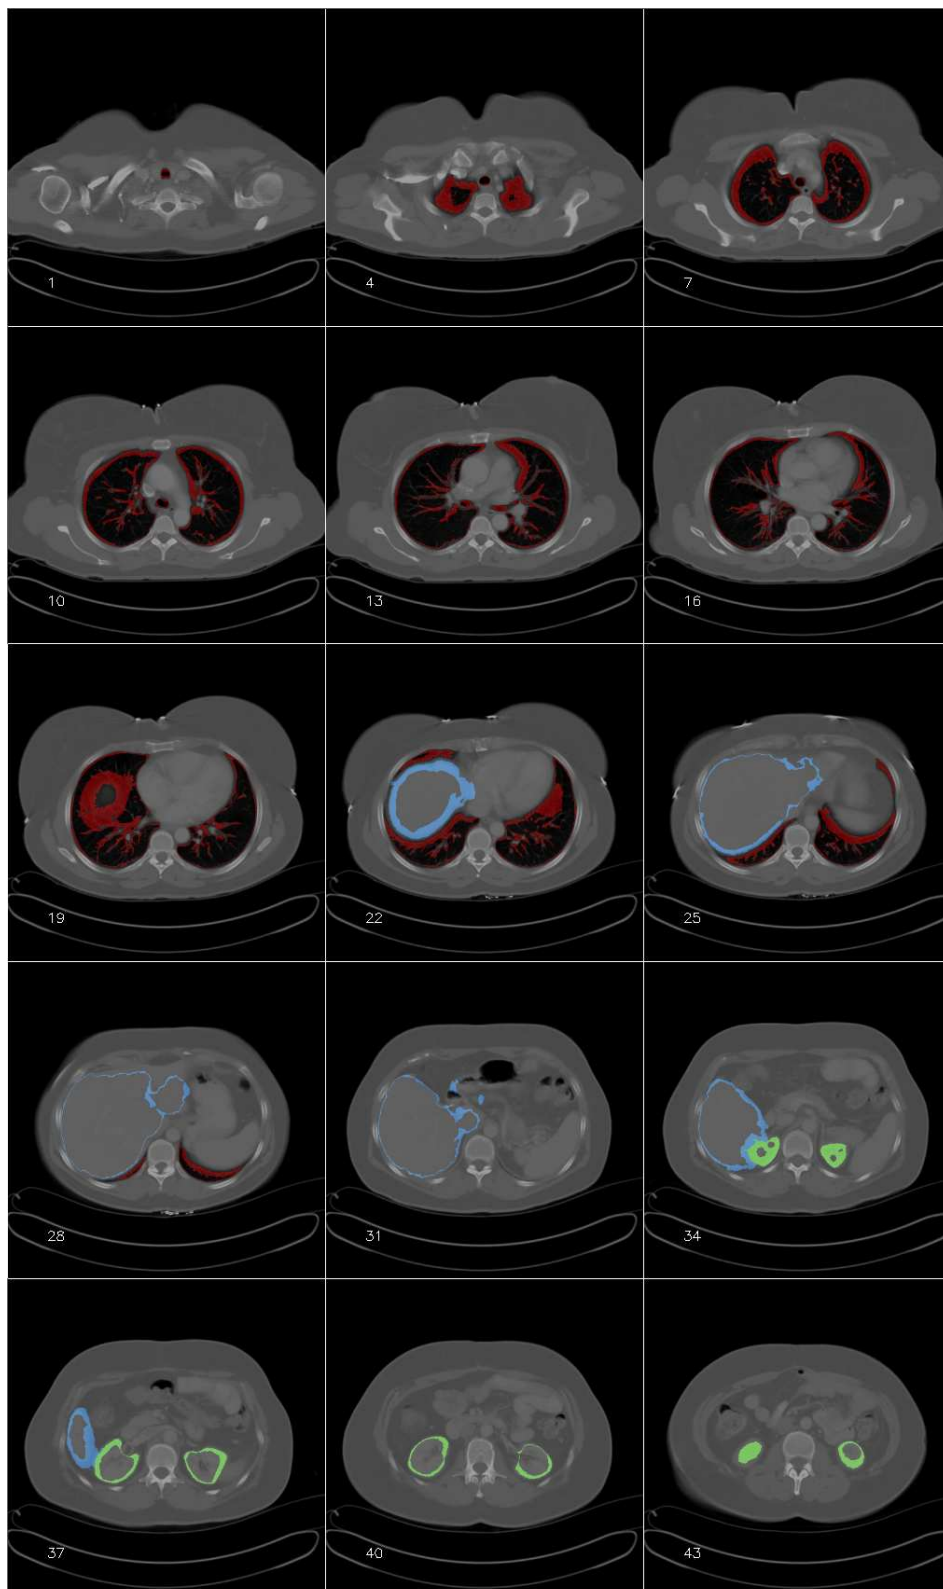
Contours of the CT segmented lungs (red), liver (blue) and kidneys (green), superimposed on 2D axial slices of the CT grey-level image.
